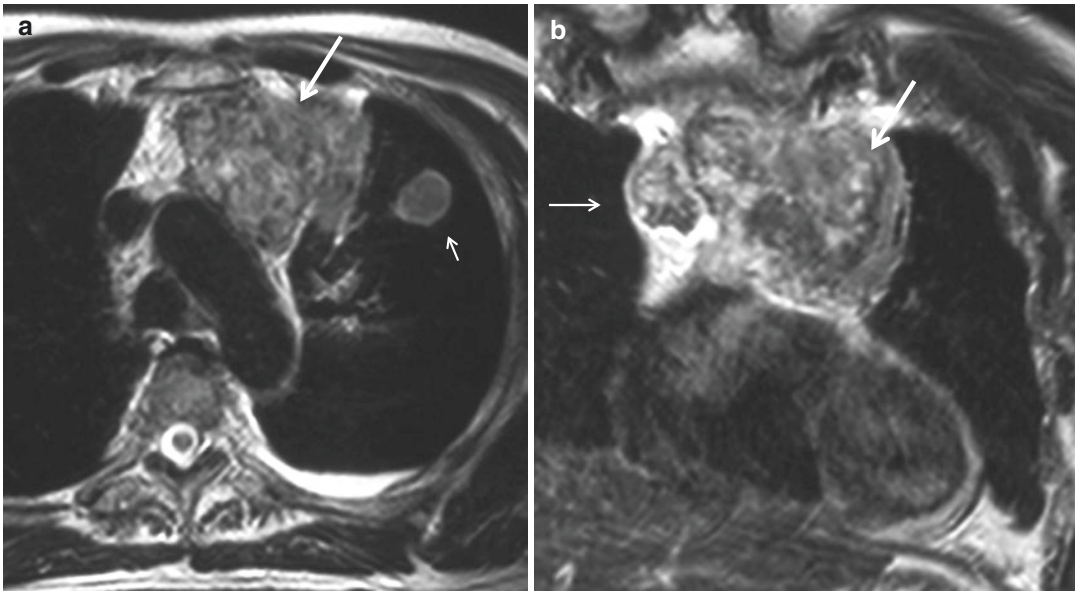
Thymic carcinoma. T2-weighted axial (a) and coronal (b) MR images show an irregular mass in the anterior mediastinum. The tumor (*large arrows*) shows heterogeneous signal intensity with foci of low signal
